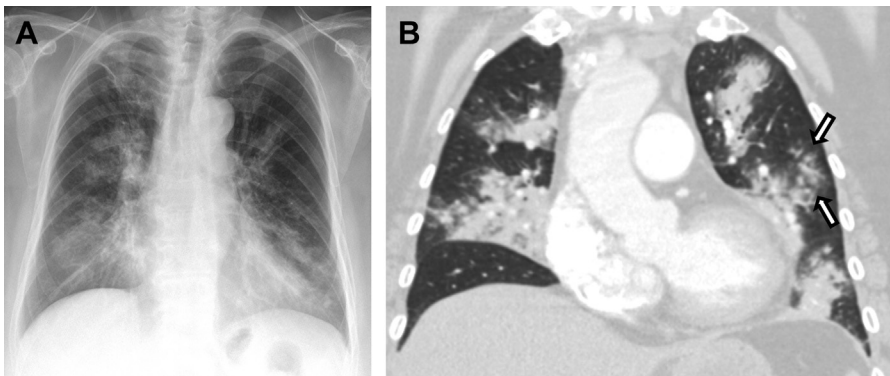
Influenza A in a 73-year-old woman. (A) Frontal chest radiograph shows bilateral centrally distributed hazy opacities. (B) Coronal chest CT demonstrates bilateral peribronchovascular consolidation consistent with bronchopneumonia. There are also small acinar nodules in the left upper lobe (arrows).
